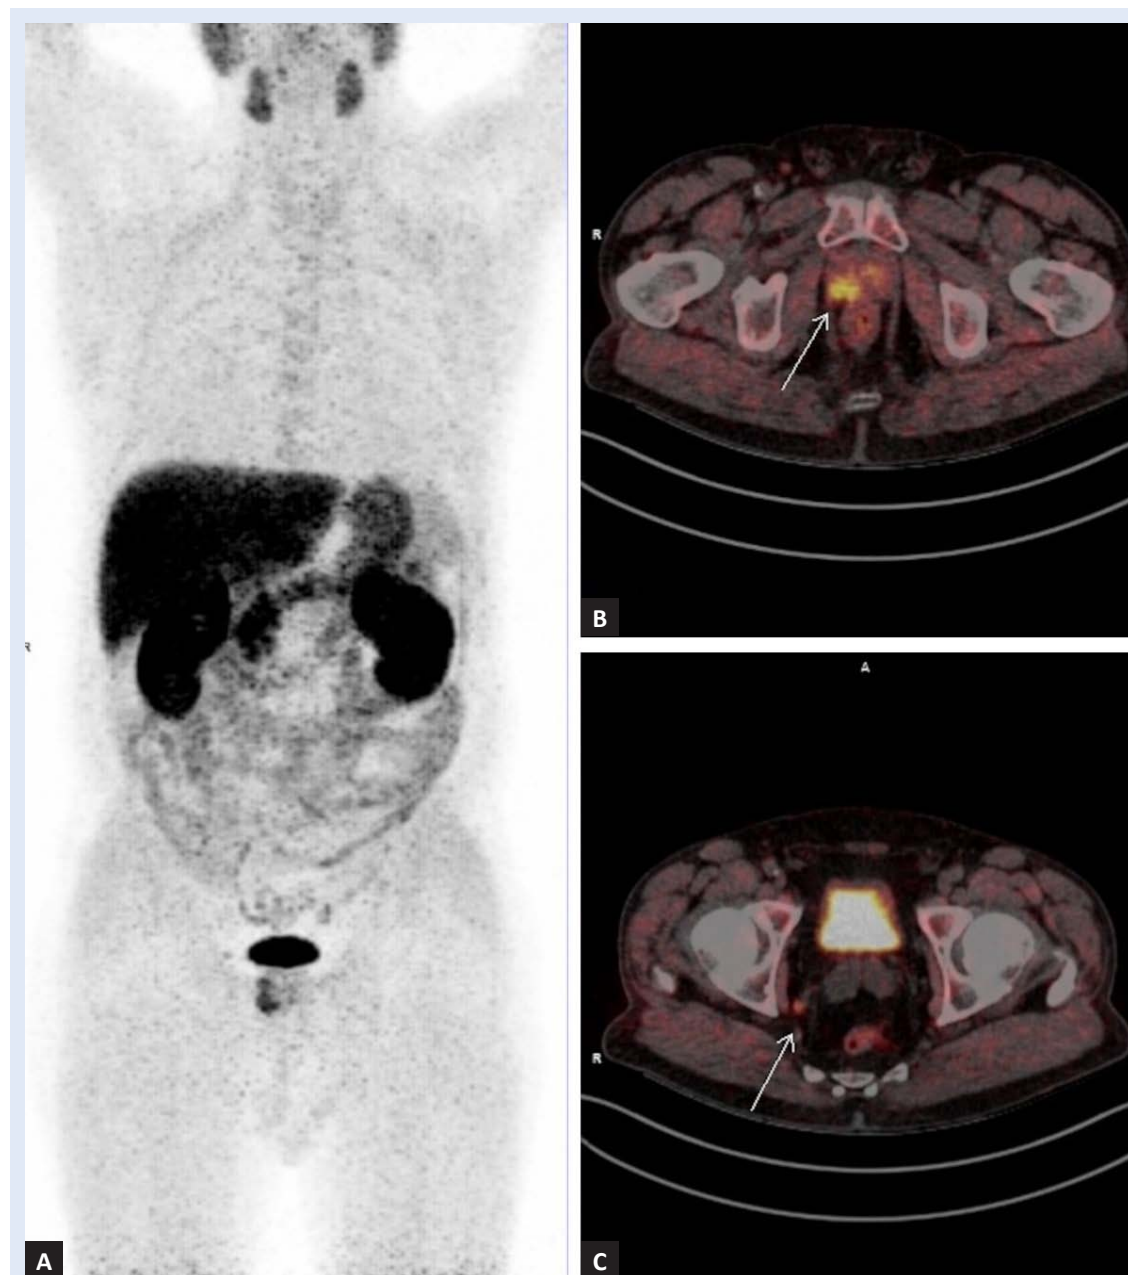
Fluorine-18 choline PET/CT imaging of 65 years old patient referred for primary staging of prostate cancer (PSA 31,7 ng/mL, Gleason score 4+3), demonstrating primary tumor and regional lymph node involvement. A: Whole body MIP (Maximum intensity projection) PET image, B-C: Axial PET/CT images showing high choline uptake in the right prostate lobe and in a small right pararectal lymph node. From the archives of the Clinical Department of Nuclear Medicine and Radiation Protection, University Hospital Centre Zagreb, Zagreb, Croatia.
